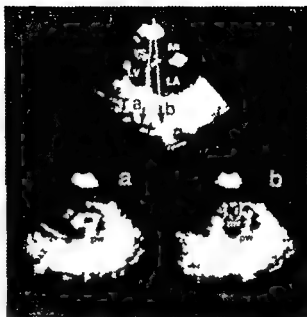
The top cross-sectional echocardiogram reveals a left ventricular longitudinal view demonstrating the ventricular septum (*h*), left ventricular cavity (*LV*), aorta (*AO*) and left atrium (*LA*). The two superimposed white lines (*a*, *b*) show the planes in which the short axis views labeled *a* and *b*^{*} (below) were derived. The short axis view labeled *a*^{*} depicts the mitral valve orifice at the mitral valve tip whereas, the short axis view labeled *b*^{*} depicts the apparent mitral valve (*me*) orifice size when the echocardiographic beam was skewed off of the mitral valve tip. View *a*^{*} represents the actual mitral valve orifice area in this patient with mitral stenosis whereas a normal mitral valve orifice area would have been predicted if the estimation was made using view *b*^{*} which was obtained off of the tip of the mitral valve. *pu* = posterior left ventricular wall.
